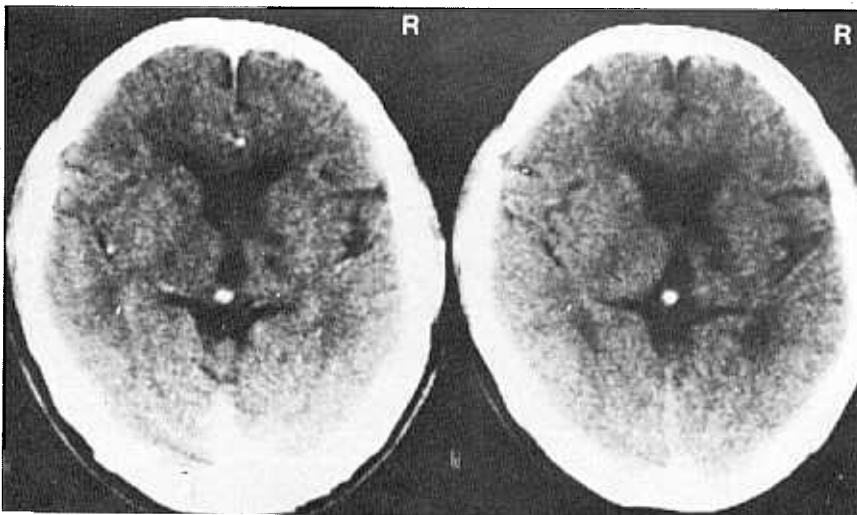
Brain CT scan of patten 1, performed at the time of CVA, showed focal low density at the right anterior thalamic area.
